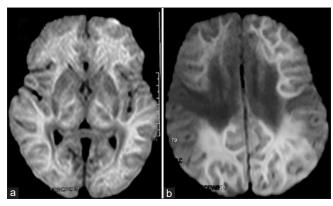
Acute encephalopathy with delayed diffusion restriction (AESD): DWI images showing diffuse white matter diffusion restriction affecting both hemispheres and posterior limb of the internal capsule (a) and central white matter and peri-rolandic sparing in "central sparing pattern" of AESD (b)
